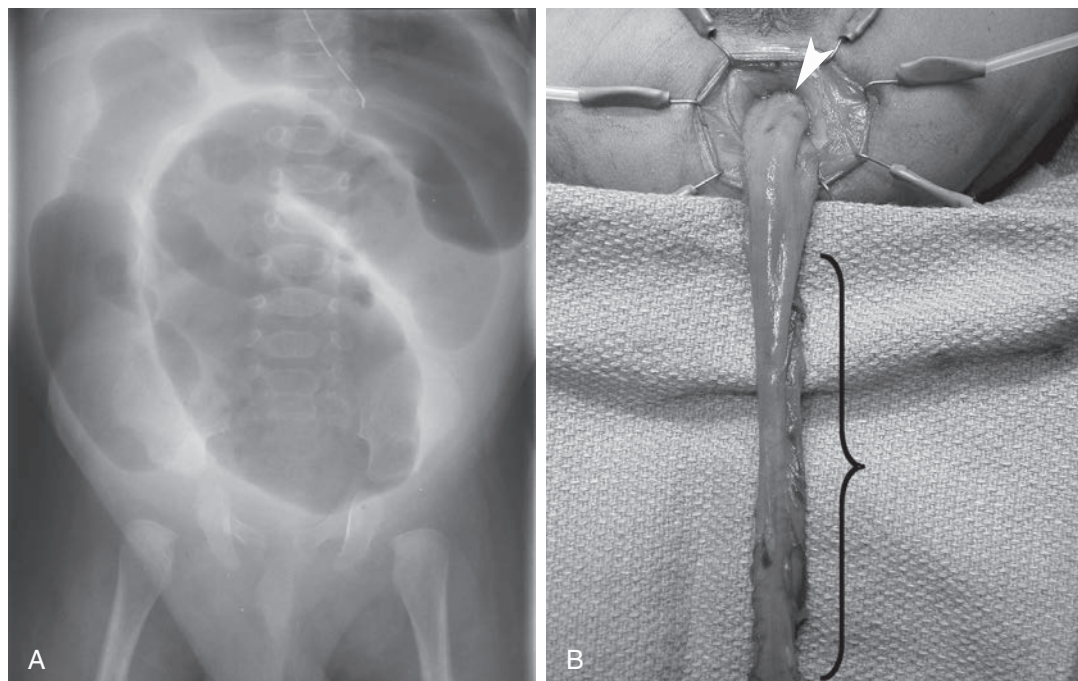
Newborn with Hirschsprung disease. A, Plain abdominal radiograph shows distal intestinal obstruction 2 days after birth in a neonate who has failed to pass meconium. Note absence of gas in rectum/pelvis. B, After laparoscopic mobilization and transanal mucosectomy, the diseased bowel may be delivered through the anus. The *bracket* denotes the contracted, aganglionic bowel. *Arrowhead* shows biopsy performed laparoscopically that confirms region of ganglionated bowel. Coloanal anastomosis was performed at this level.
